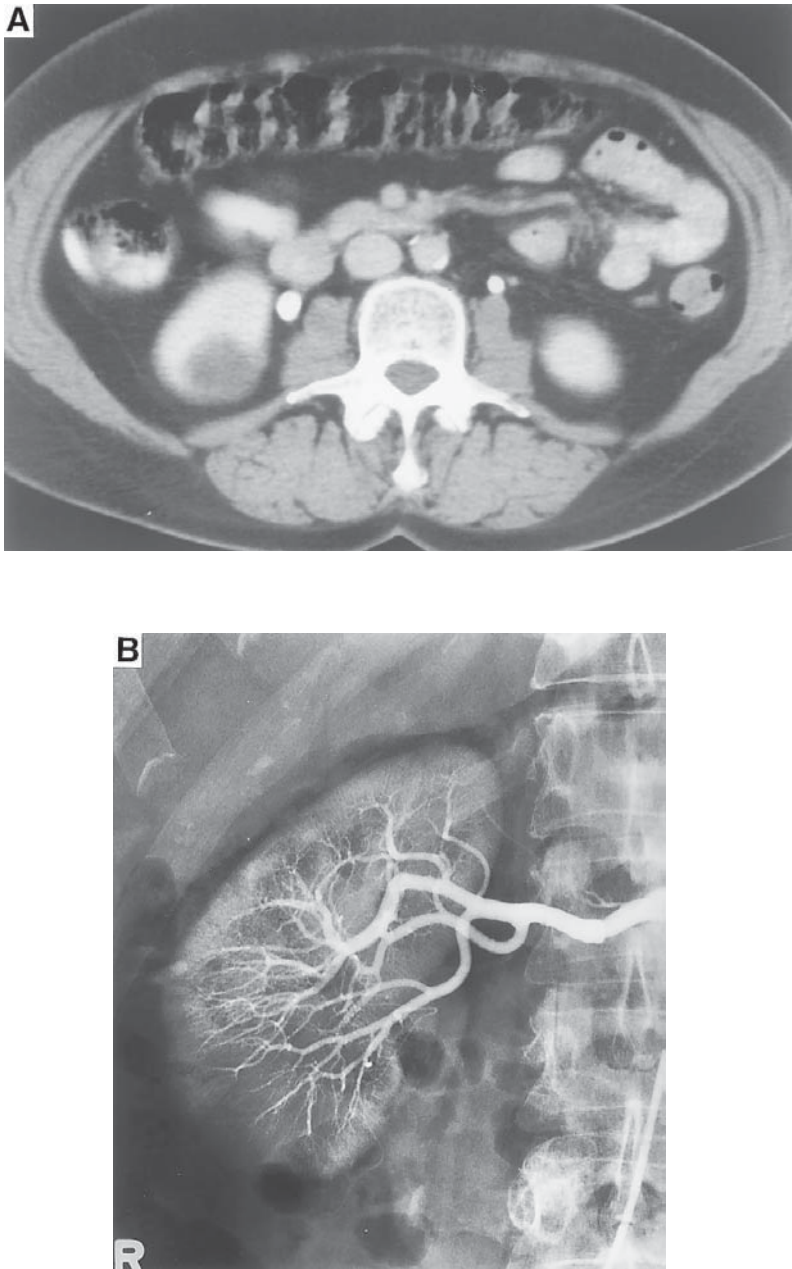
CT scan (A) and arteriogram (B) of a solid but hypovascular mass.
